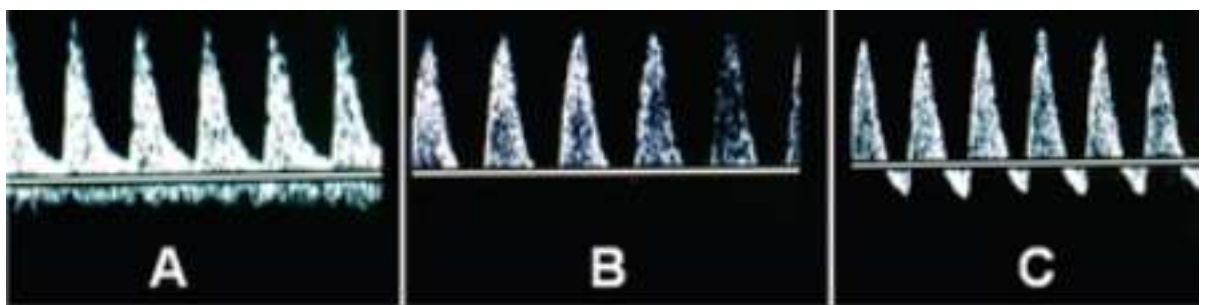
Abnormal UA Doppler image
